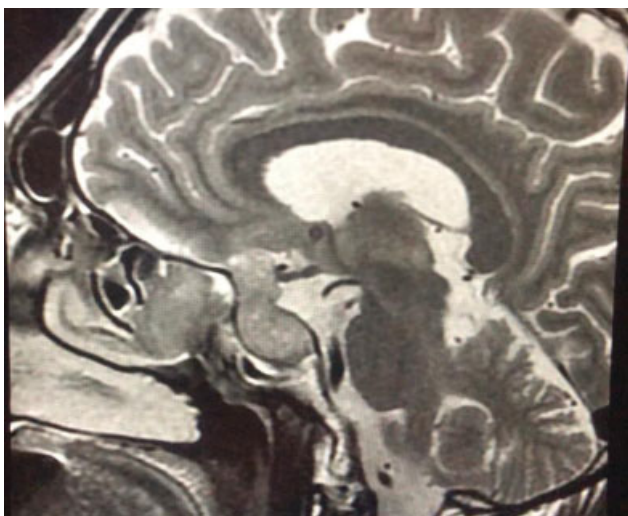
T2-weighted sagittal MRI showing anterior lesion in the nasal cavity (carcinoma) and posterior lesion in the sellar / suprasellar region (adenoma).
